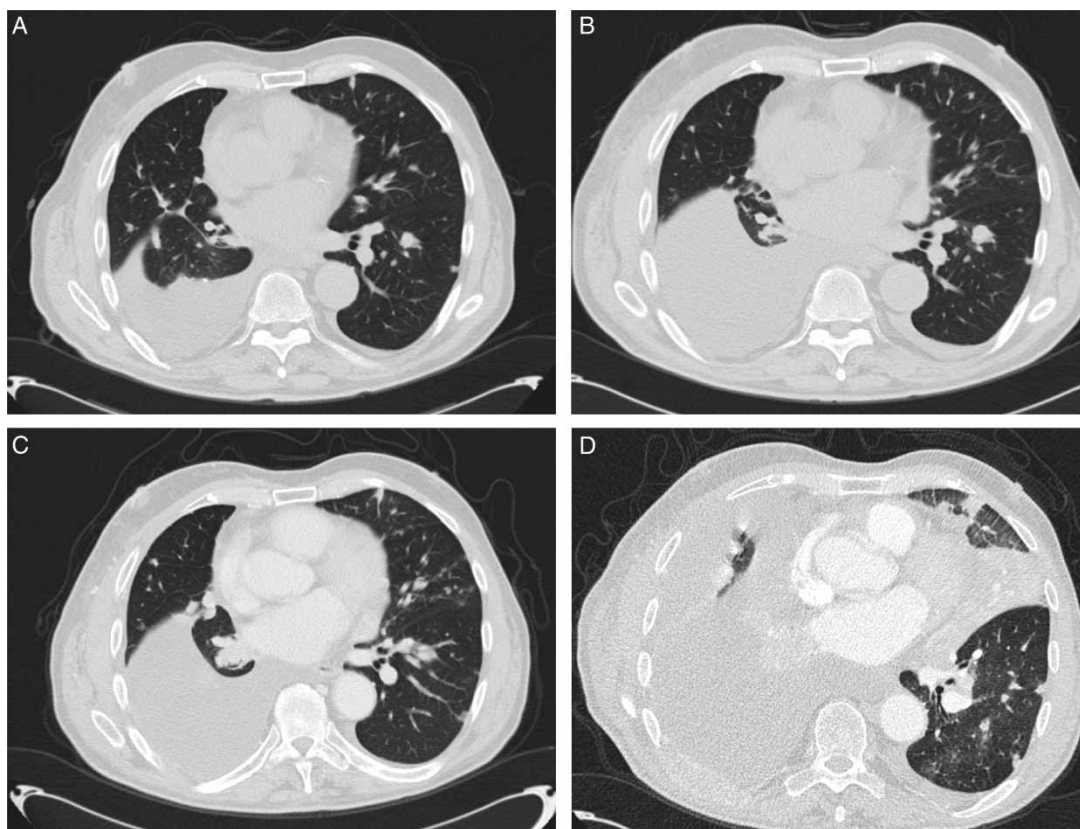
Patient 1. A. Pleural and intrapulmonary metastases with pleural effusion, short before discontinuation of sorafenib. B. Progression of number and size of pulmonary metastases with increased pleural effusion, one week after discontinuation of sorafenib. C. Latest CT before the second stop of sorafenib. D. Progressive disease after discontinuation of sorafenib with pulmonary, pleural and lymph node metastases, pleural and pericardial effusion.
